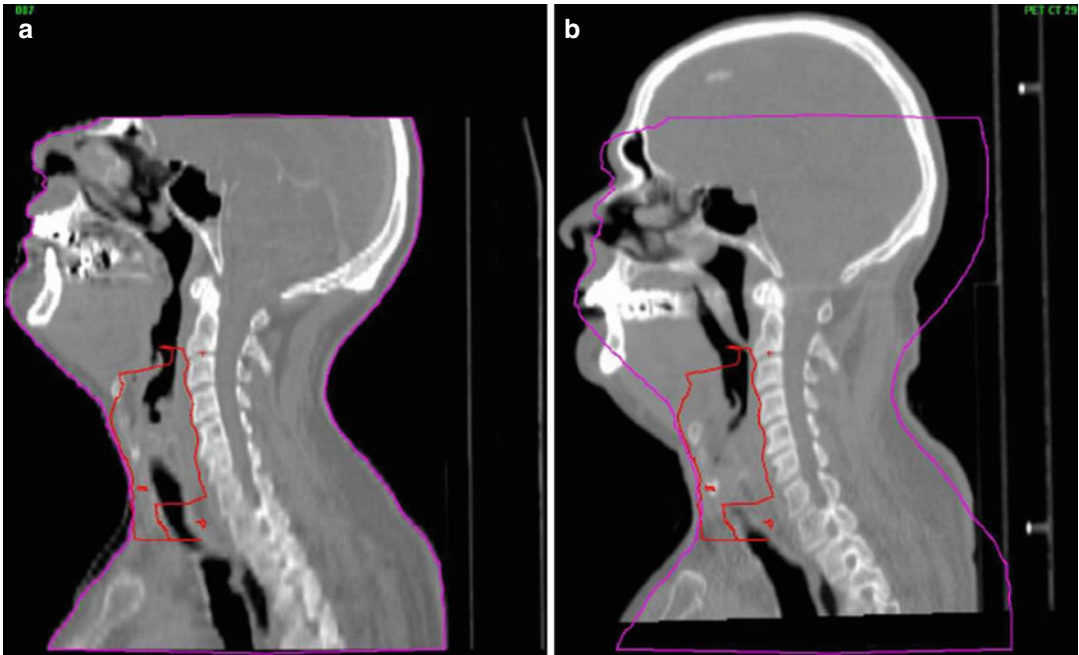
Importance of patient position for target volume delineation. (a) Sagittal reconstruction of the planning CT scan of a patient with laryngeal cancer in radiotherapy treatment position secured by positioning aid (mask), CTV marked in red. (b) Sagittal reconstruction of CT
